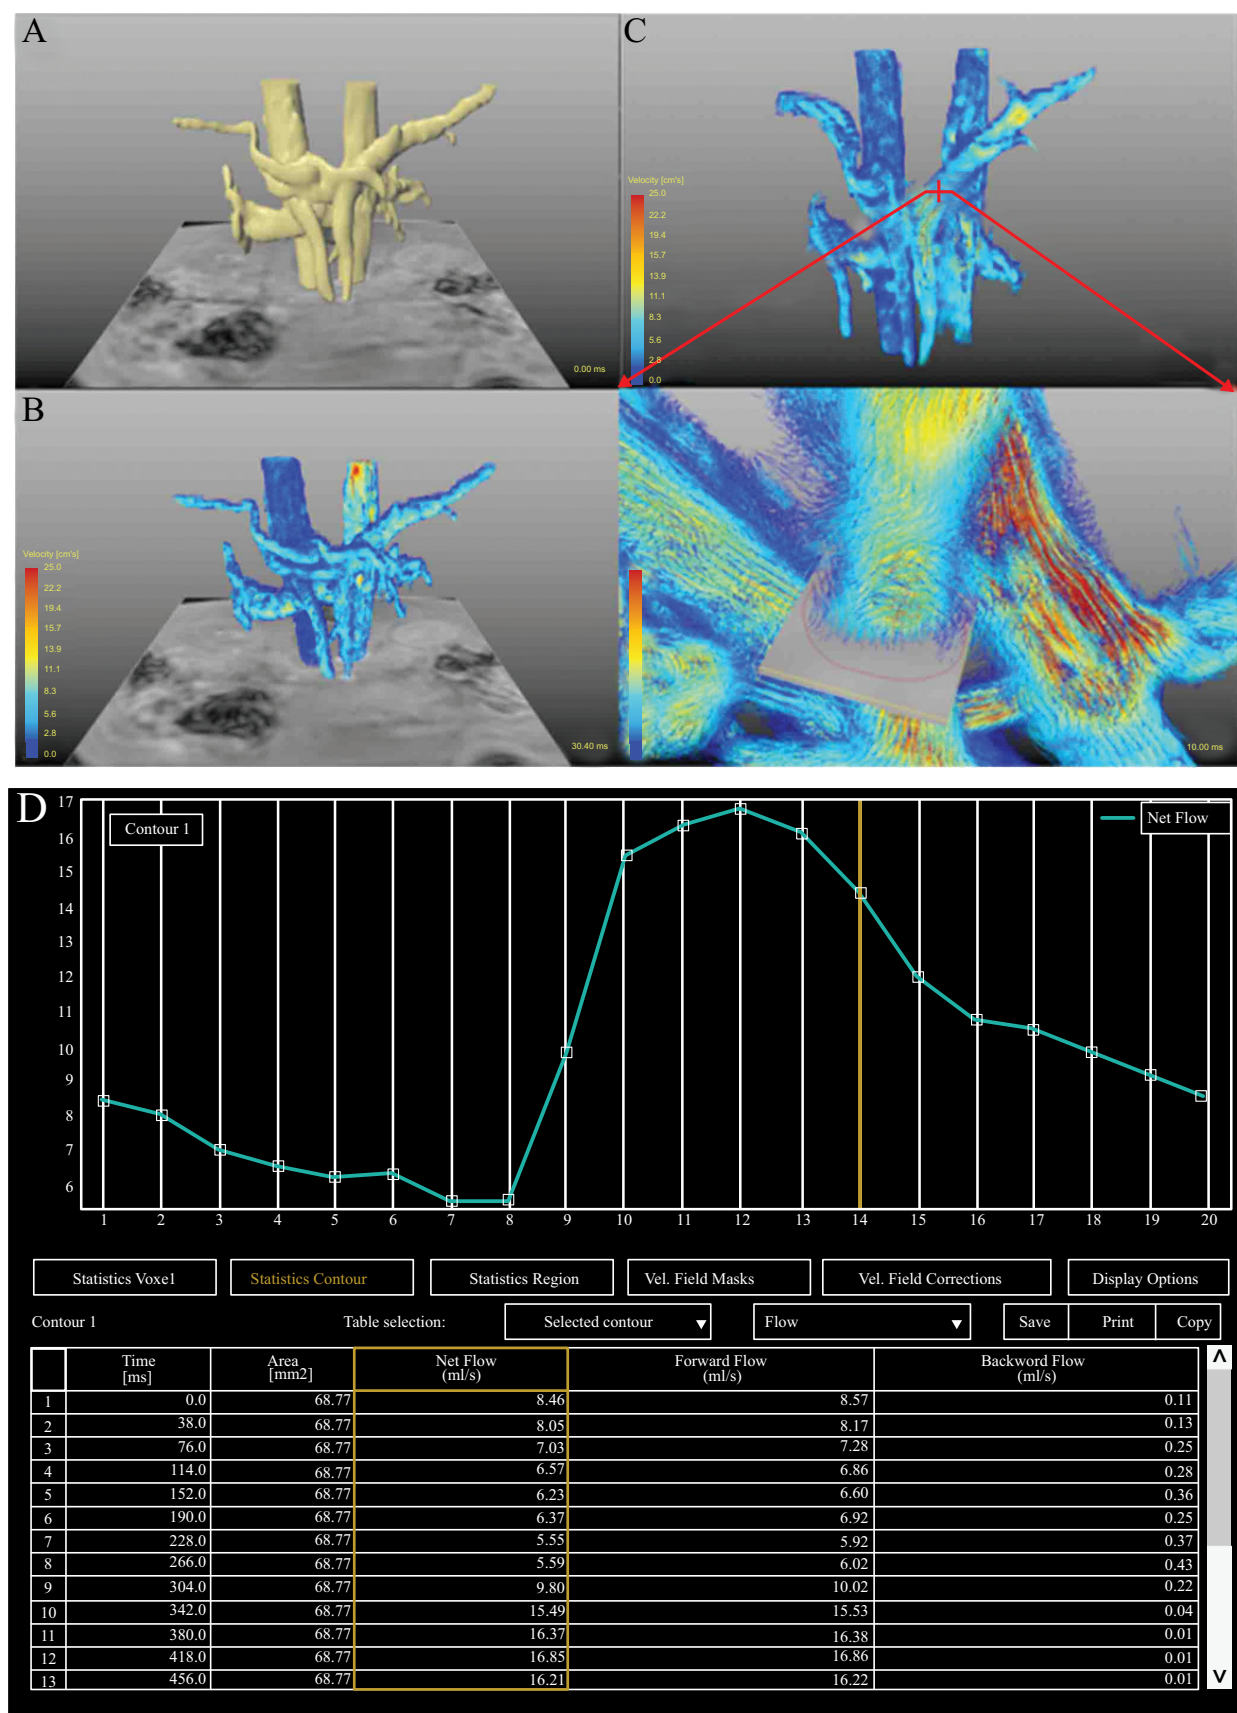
Measurement of visualized hemodynamic parameters in 4D flow MRI. (A). Visual images after vascular segmentation; (B). Streamline observation based on visual vascular images; (C). Selection of vessel cross section; (D). 4D flow MRI measurement of hemodynamic parameters.
